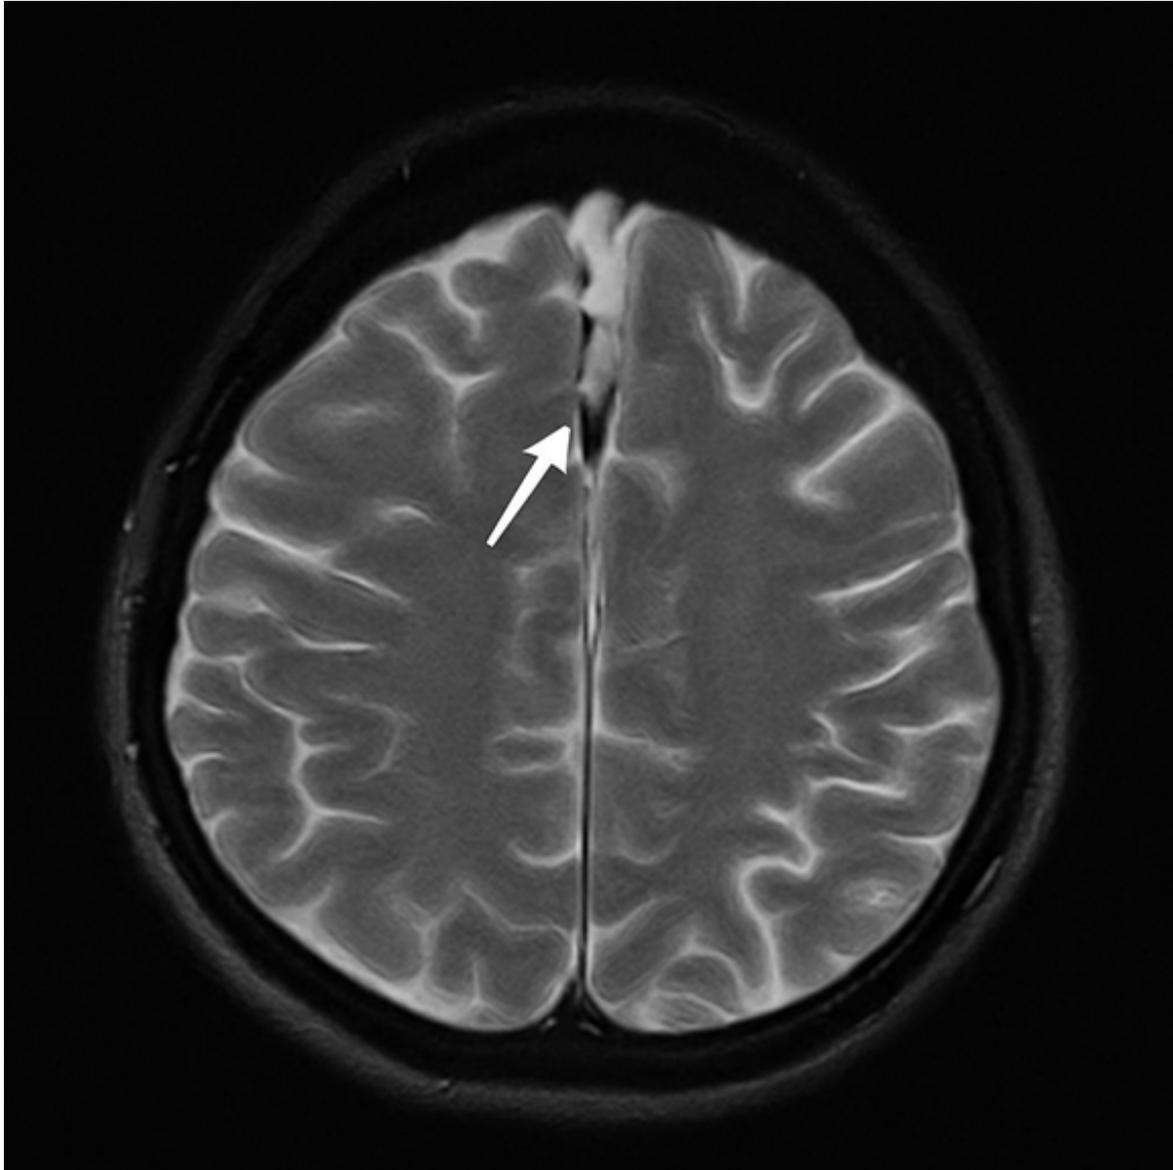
Axial T2-Weighted Magnetic Resonance Imaging (MRI) of the Brain
